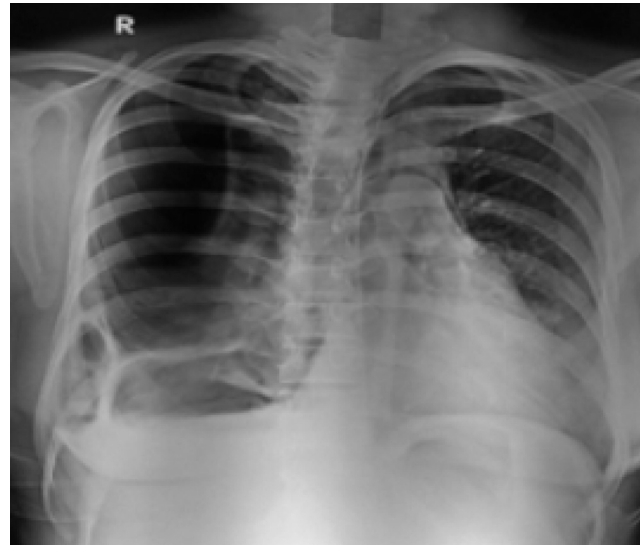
Chest radiograph (postero-anterior view) obtained during the fourth episode showing right-sided pneumothorax with right upper zone pleural thickening.
